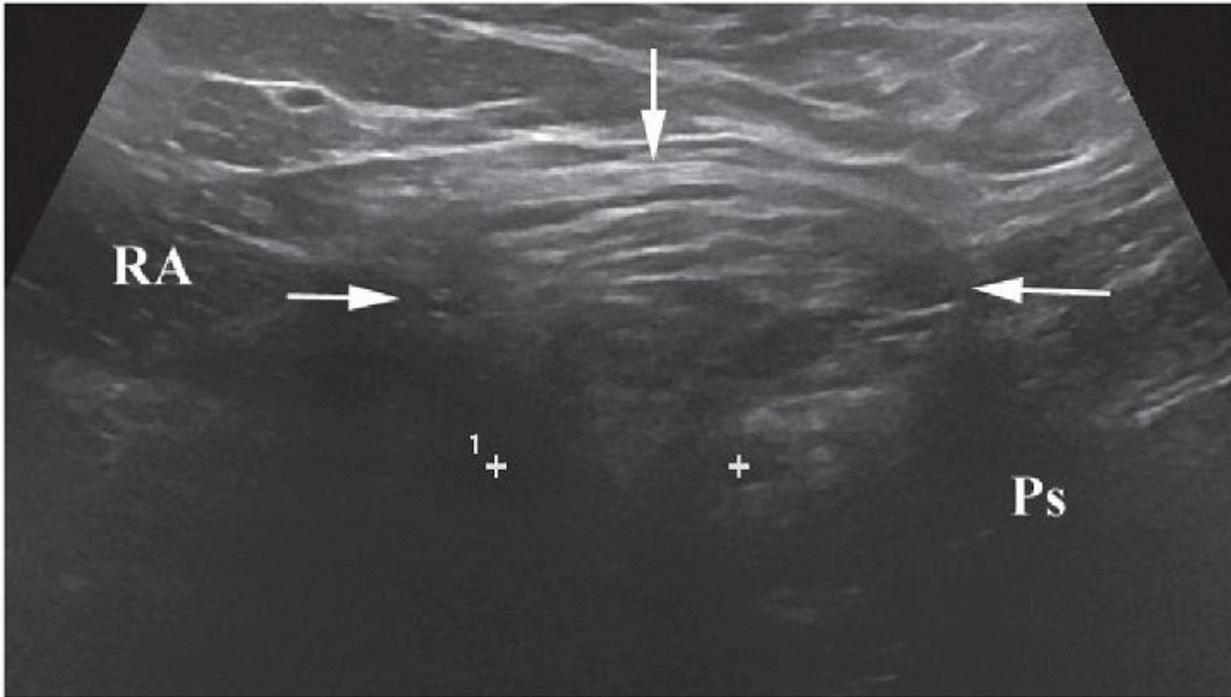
Direct inguinal hernia. Transverse sonogram of the inguinal canal shows direct inguinal hernia (arrows) extending through a posterior wall defect (calipers) into the canal. Note the rectus abdominis (RA) and iliopsoas (Ps).
